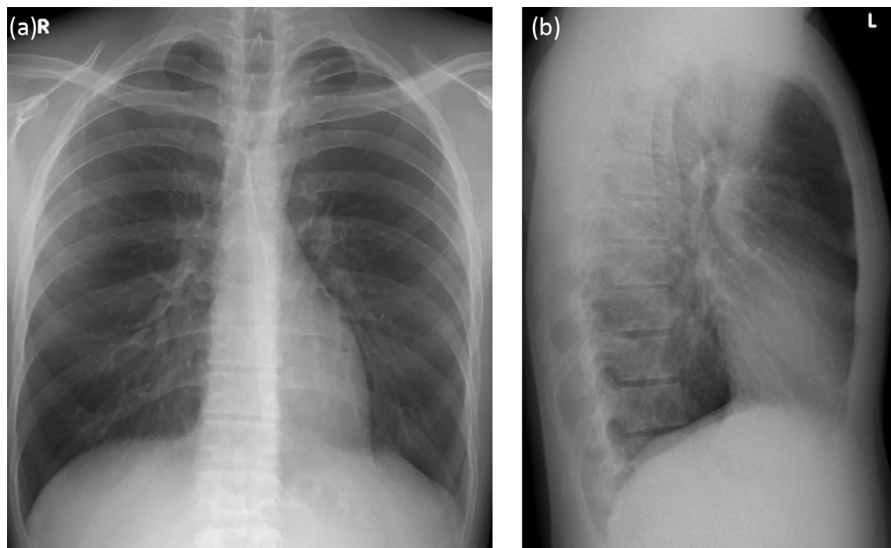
Follow-up chest x-ray on posteroanterior (A) and lateral (B) projections, performed 48 days after initial hospitalization, was unremarkable.
